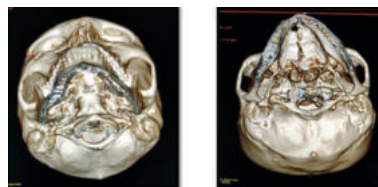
3-D Skull View (CT-Scan)
